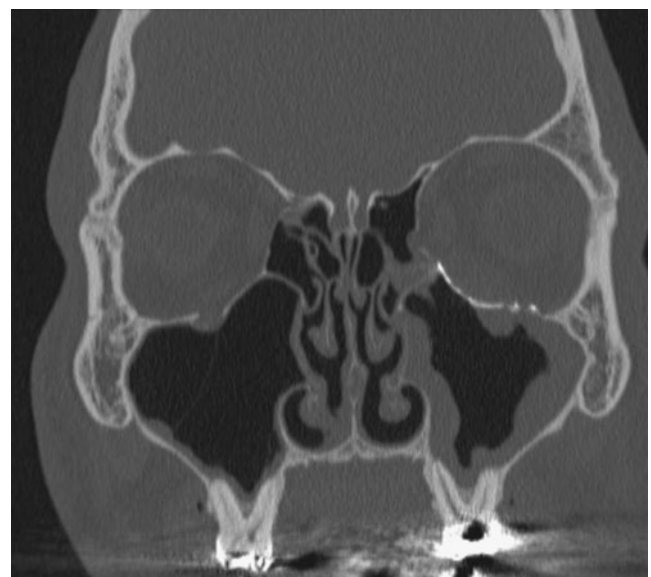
Coronal CT scan after orbital floor repair with a titanium mesh
